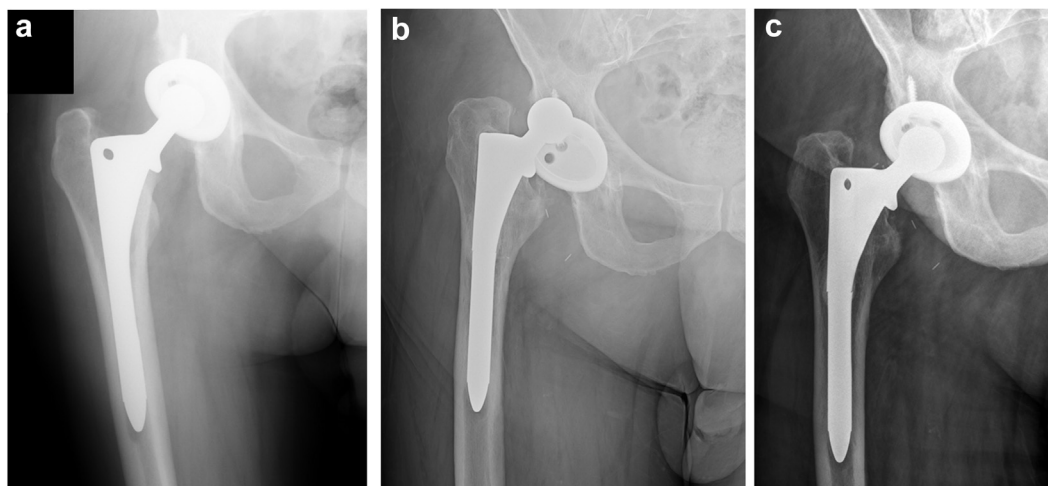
Postoperative radiographs after THA in a patient with EDS (a). The patient suffered 3 dislocations postoperatively, along with a fracture in the femoral stem (b). The patient was treated nonoperatively and underwent a functioning THA 20 years after the index procedure (c).
